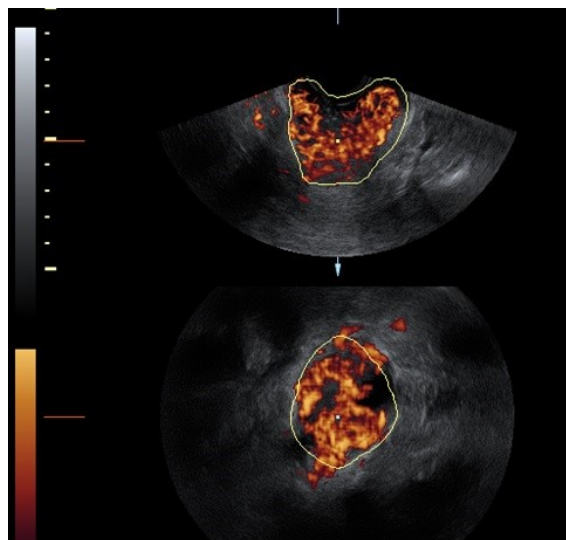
Example of 3D Doppler image for a cervical cancer patient. Grey scale represents the morphology, while color scale is related to the presence of flow in the corresponding area.
